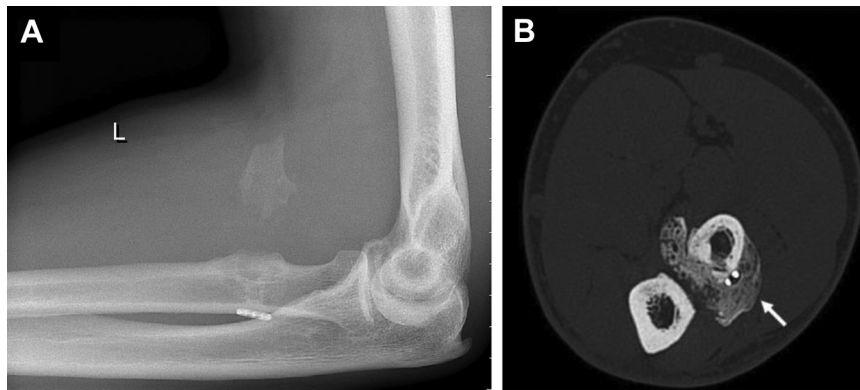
(A) Lateral view: postoperative radiograph following distal biceps tendon repair with presence of heterotopic ossifications (single-incision cortical button). (B) Axial-view computed tomographic scan: arrow pointing at radioulnar synostosis (different patient).
